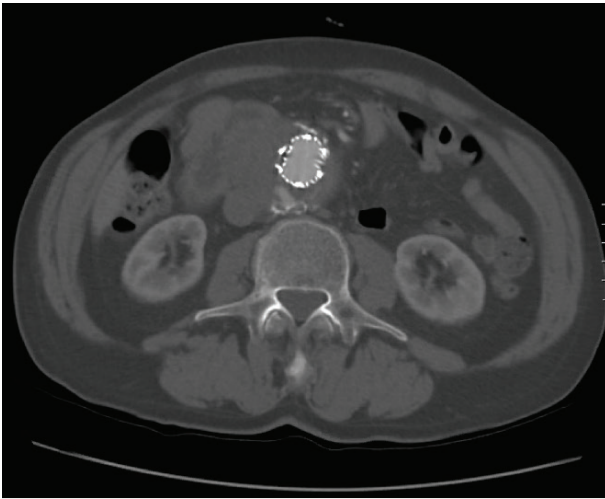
CTA demonstrating type II endoleak from paired lumbar arteries after EVAR. Note the proximity of the IVC to the aneurysm sac.
